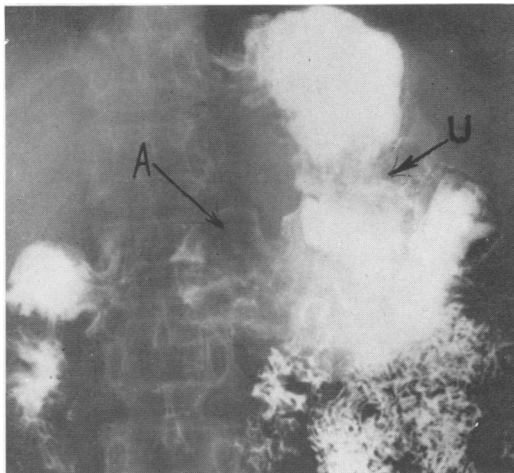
A roentgenogram of patient 28 taken 3 months after a 70% gastric bypass for treatment of acid peptic disease, shows at A, stasis in the excluded segment and at B, an ulcer at the gastroenterostomy stoma. At reoperation the excluded segment had pulled away from its attachment to the fundic portion.
